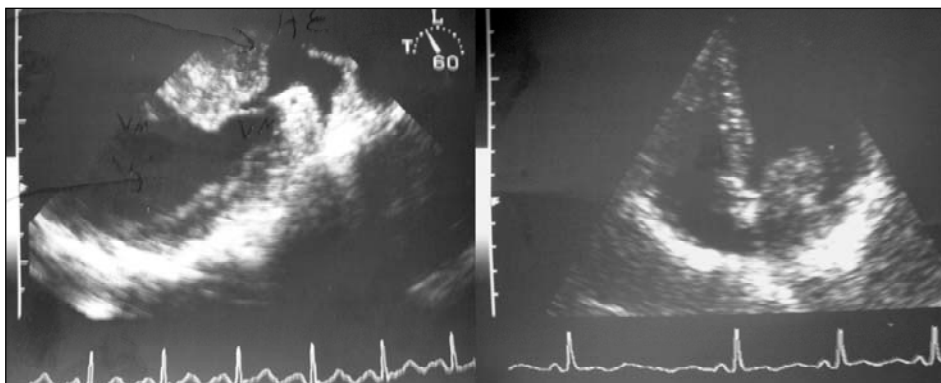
Transesophageal echocardiogram: left atrial myxoma measuring 38x26 mm, irregular surface, jutting out at entrance of the left ventricle during diastoles, with normal mitral valve flux; normal cavities, dimensions and dynamics, without spontaneous contrast in atrium; septum without solution of continuity; aorta with normal morphology.
